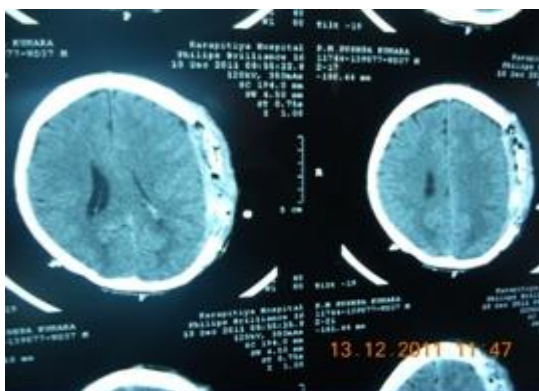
Repeat CT with extra dural haemorrhage and mid line shift (CT scan image)
